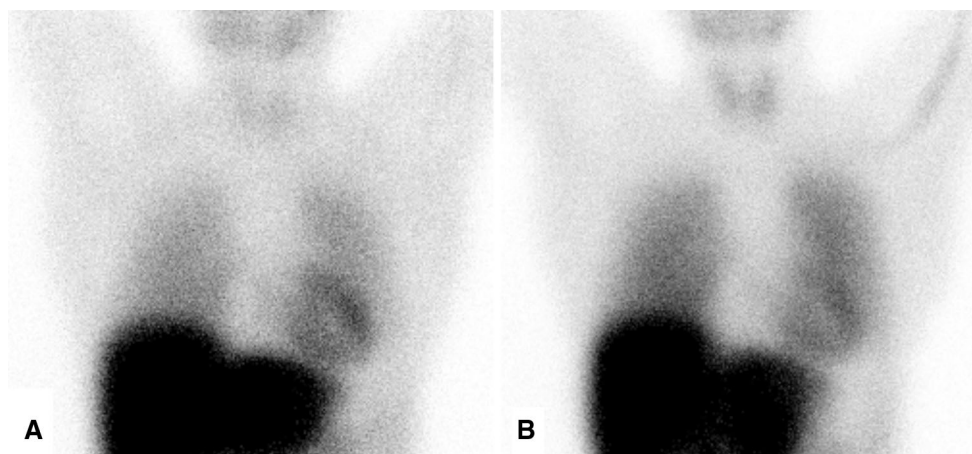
Normal [^{123}I]-MIBG scintigraphy in a patient with AL amyloidosis: a early image acquired after 15 min after tracer administration, b late image acquired after 4 h post injection. Both
